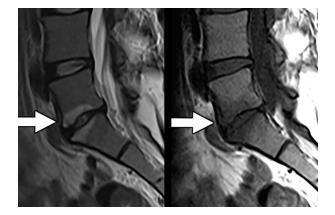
MRI shows Modic changes of the vertebral endplates above and below the disc.
